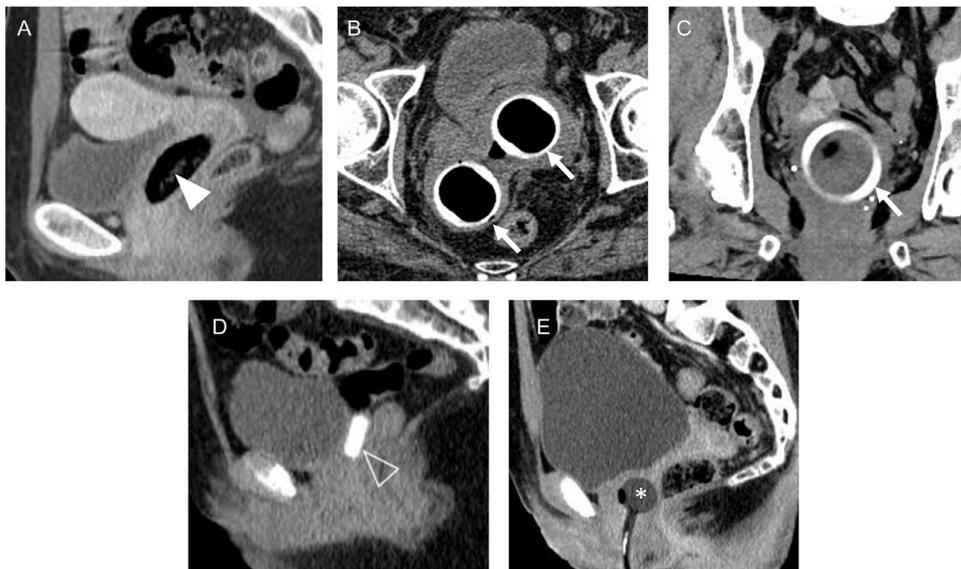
Foreign bodies are commonly encounter in the vagina. (A) sagittal CT image shows a mixed attenuation tubular tampon predominately composed of gas in the vagina (arrowhead). (B) and (C) axial and coronal CT images of different patients with pessary devices in the vagina (arrows). (D) sagittal CT image shows a rectangular hyperdense foreign body in the vagina which on physical exam was a piece of candy (open arrowhead). (E) sagittal CT image shows a urinary catheter inadvertently placed in the vagina (asterisk).
